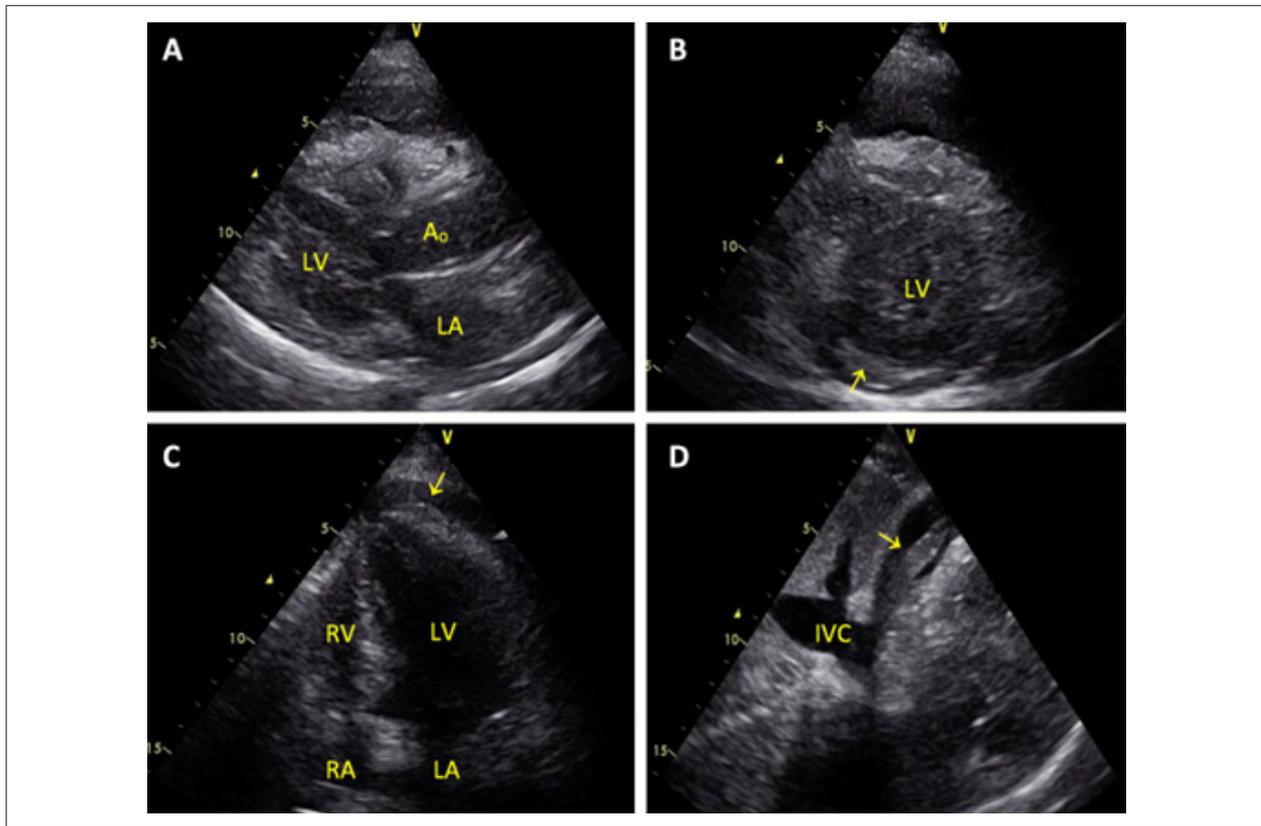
Transthoracic echocardiogram. (A) Parasternal long-axis and (B) Parasternal short-axis views showing a mild hypertrophic and non-dilated left ventricle; (C) Apical 4-chamber view showing a partial collapse of right cavities and a lateral hypokinesia but preserved systolic function of the left ventricle; (D) Subcostal view showing a dilated inferior vena cava, with no respiratory size variation. The yellow arrow indicates a moderate pericardial effusion. LV: left ventricle; LA: left atrium; Ao: Ascending aorta; RV: right ventricle; RA: right atrium; IVC: inferior vena cava
